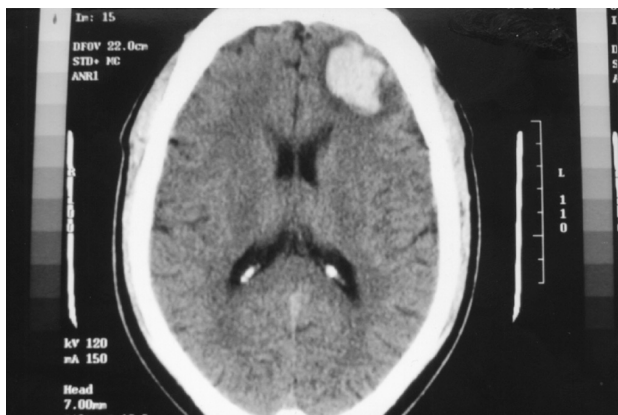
Non-contrast CT scan showing an acute intracerebral bleed in the left frontal lobe.
